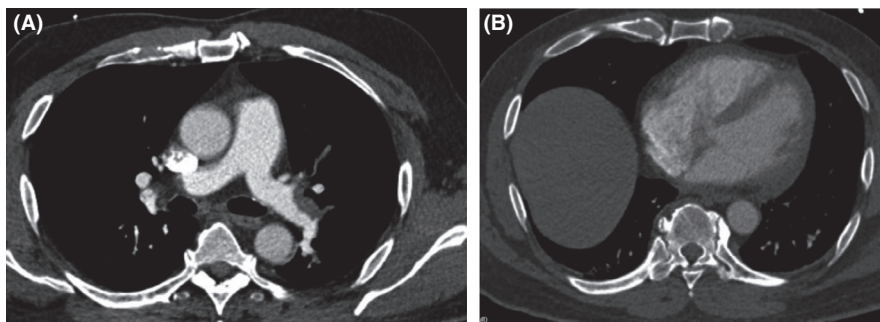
Follow-up CT scan shows no residual clot in PA and reduced RV/LV diameter ratio
